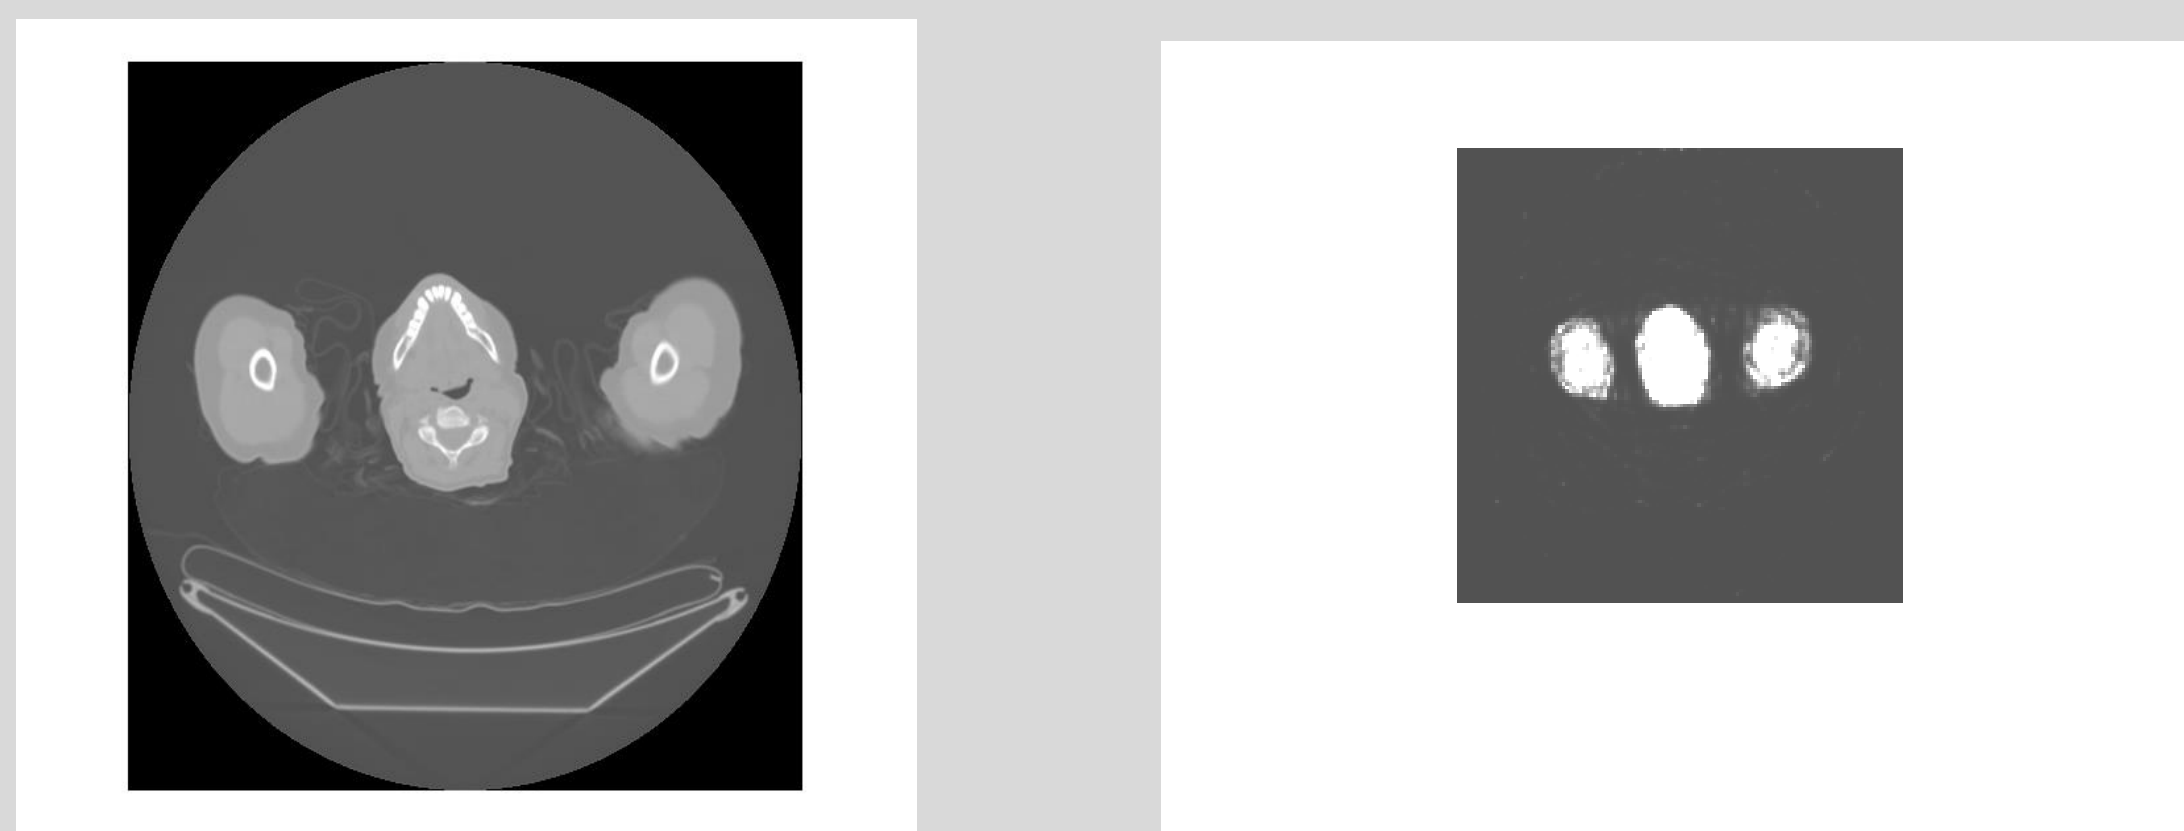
Corresponding baseline (pre-treatment) CT and PET images.
